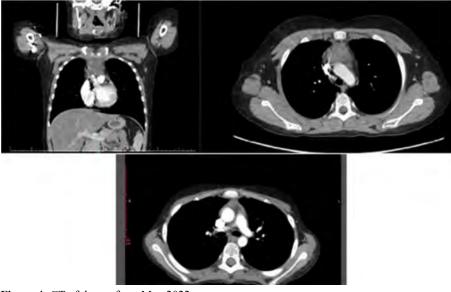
CT of thorax from May 2022.
